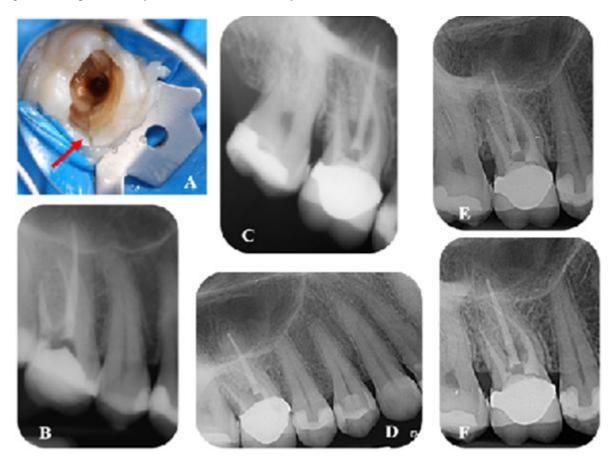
Monitoring of a tooth with coronal fracture line (*red arrow*) and radicular crack: A/ Intraoral image to coronal crack (*red arrow*); B/ Control radiograph after root canals obturation; C/ Post operative radiograph - 6 months after endodontic treatment; D/ 2 years after treatment; E/ 4 years after treatment; F/ 6 years after treatment.
